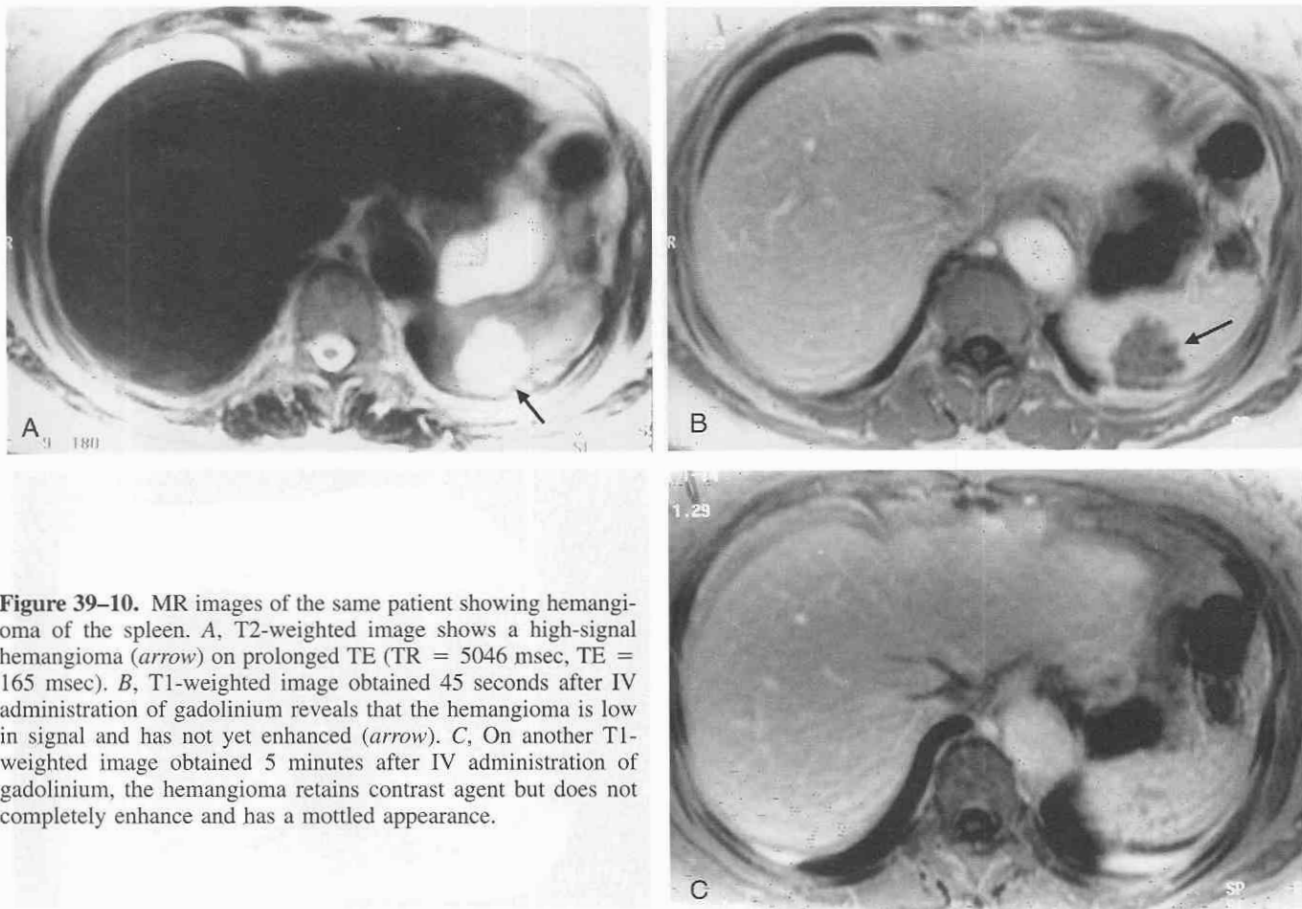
MR images of the same patient showing hemangioma of the spleen. A, T2-weighted image shows a high-signal hemangioma (arrow) on prolonged TE (TR = 5046 msec, TE = 165 msec). B, T1-weighted image obtained 45 seconds after IV administration of gadolinium reveals that the hemangioma is low in signal and has not yet enhanced (arrow). C, On another T1-weighted image obtained 5 minutes after IV administration of gadolinium, the hemangioma retains contrast agent but does not completely enhance and has a mottled appearance.
